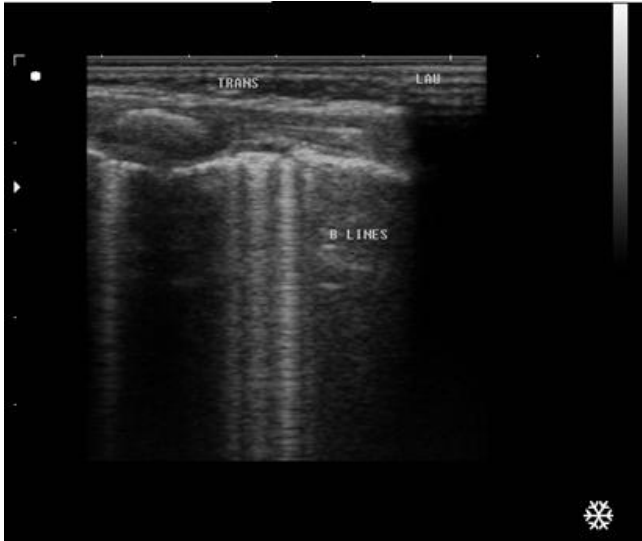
Three months old male baby with fever cough and difficulty in breathing, sonography shows more than three discrete laser-like vertical hyperechoic reverberation artifacts that arise from the pleural line (significant B lines).
